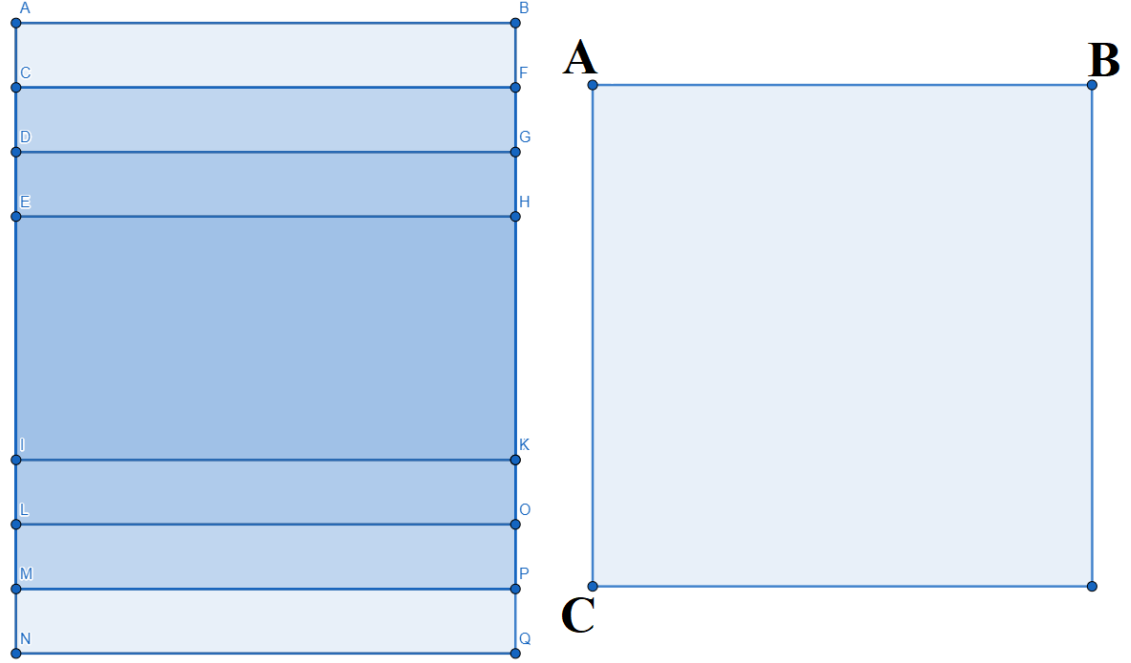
The stereo overlap produced from the parasternal column of ultrasound transducers. The left image shows the total view of the four transducers while the right image is only the stereo overlap area minus the non-overlapped areas (the top and bottom lightest rectangles).
